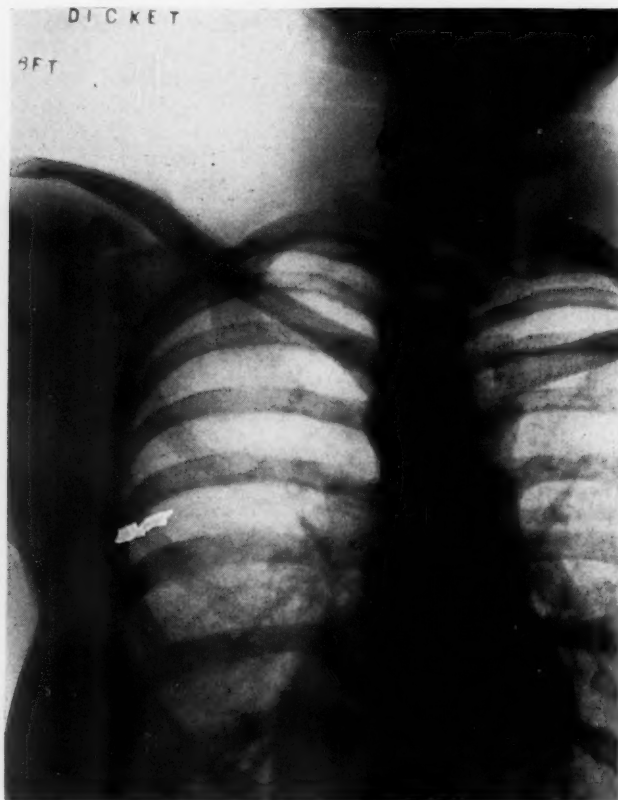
Preoperative roentgenogram, showing cervical rib in Case II as a direct shadow running from the seventh cervical transverse process down to and articulating with the rib just above the shadow of the clavicle.
